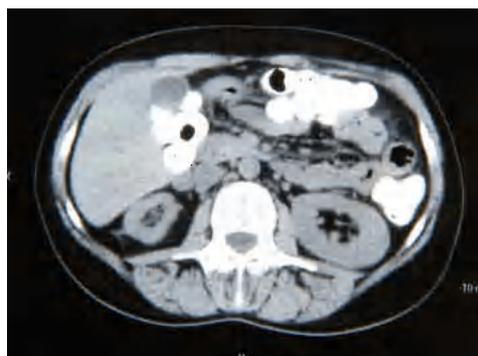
CT scan two months after the onset of treatment
